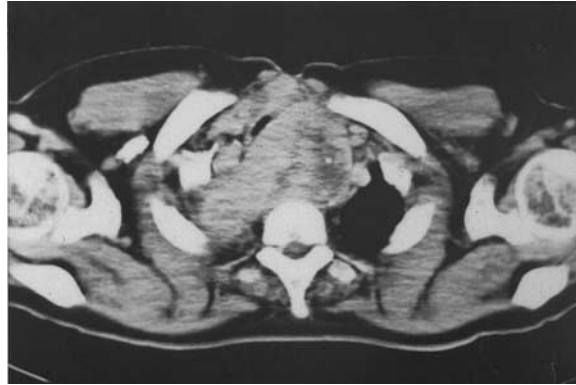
Neck CT demonstrates invasion of the trachea and other adjacent neck structures by direct invasion.
